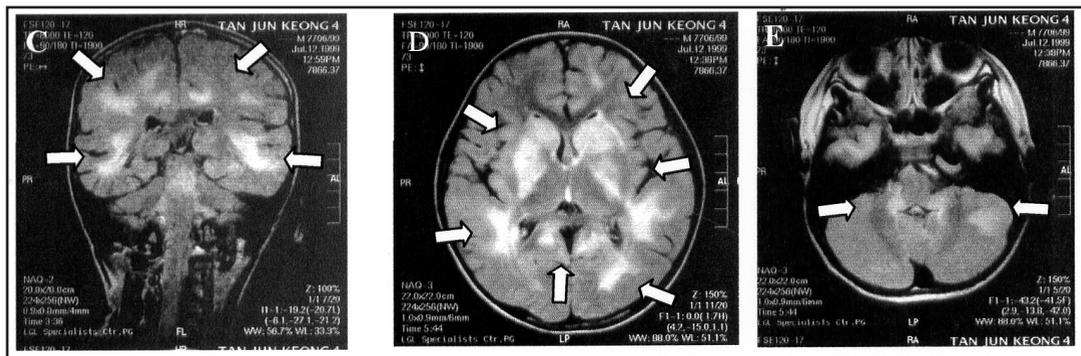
(Case 2): Magnetic resonance FLAIR coronal (C) and axial (D,E) images showing hyperintense signals in the subcortical and deep white matter of the right and left frontal, parietal and temporal lobes, basal ganglia, pons, and in the cerebellar hemispheres (white arrows).
